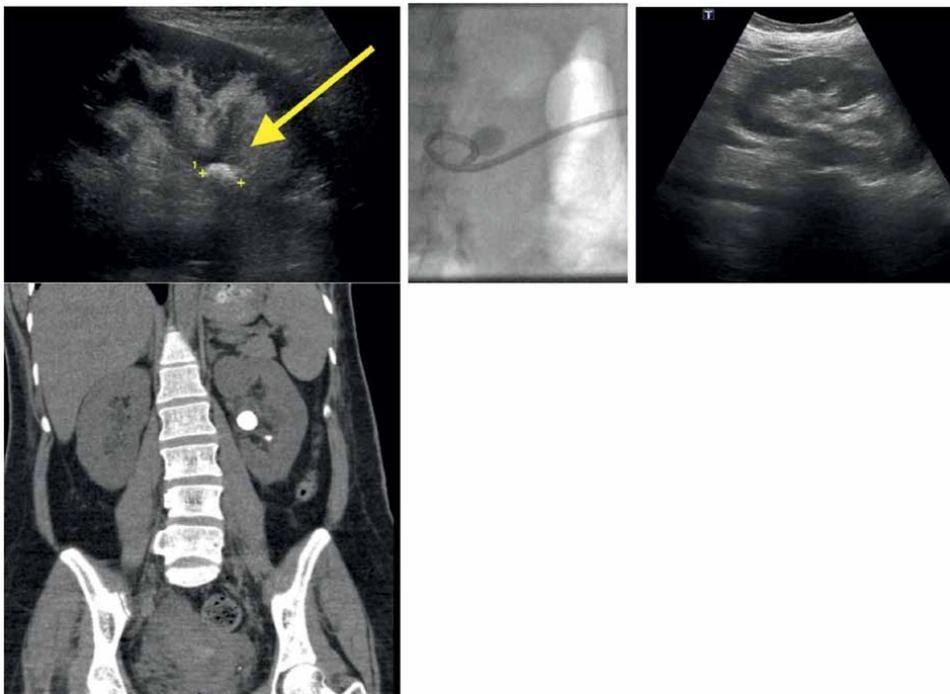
A 27-year lady, 24 weeks pregnant presented to the emergency room with intractable pain, vomiting, and fever. Conservative management failed. Her ultrasound (A) showed hydronephrosis and renal pelvic stone 15 mm. In view of failure of conservative treatment, a PCN was placed (B) and subsequent ultrasound (C) showed resolution of hydronephrosis, stone (arrow) and PCN. Postpartum CT (D) confirmed the presence of stone, and she underwent an unremarkable mPCNL.
